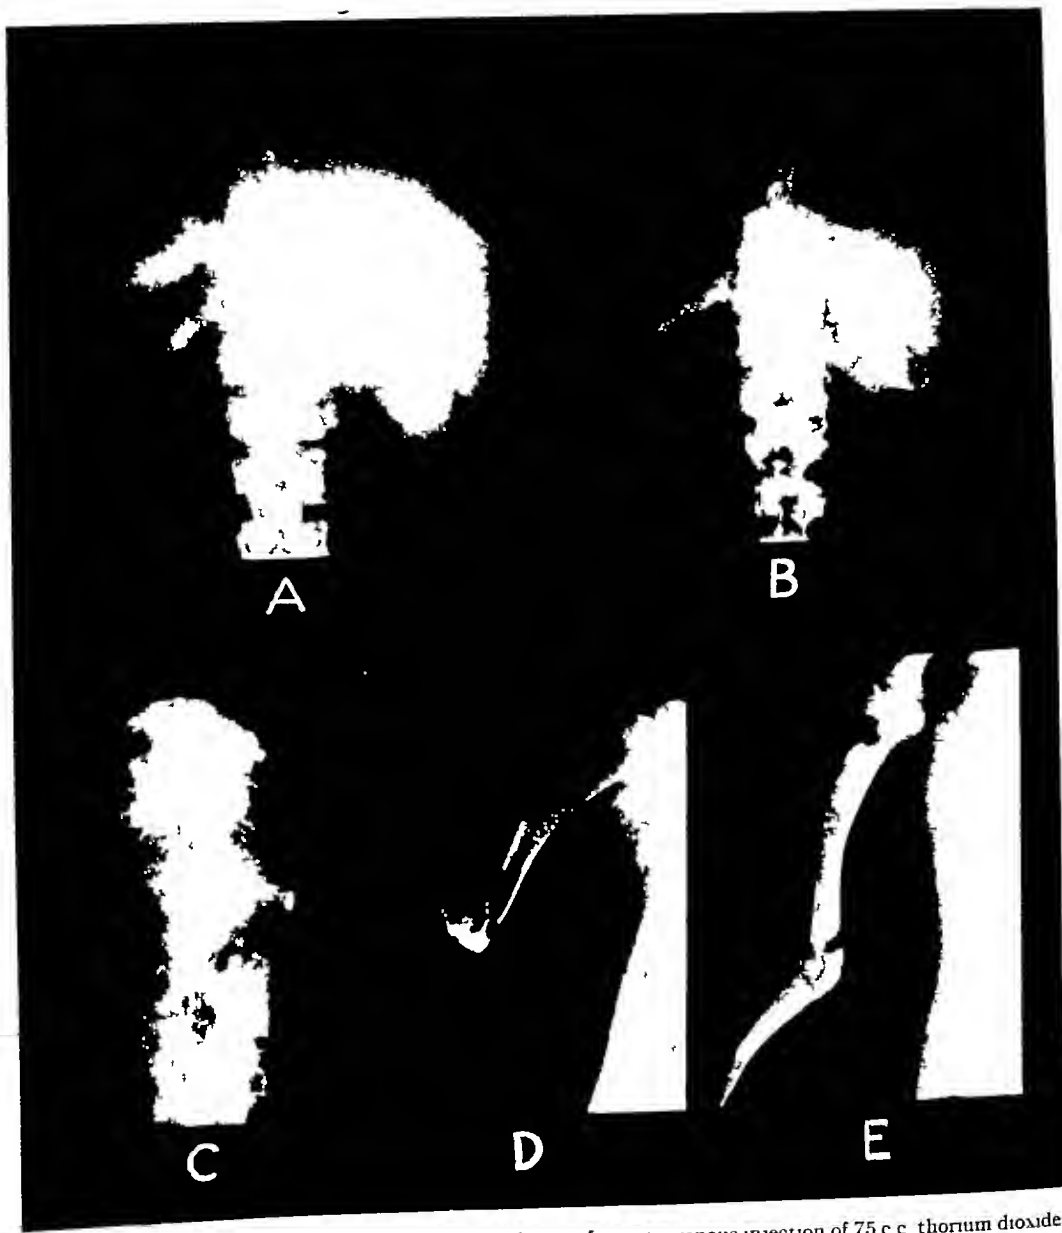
A Roentgenogram of a patient taken 24 hours after intravenous injection of 75 c c thorium dioxide sol
